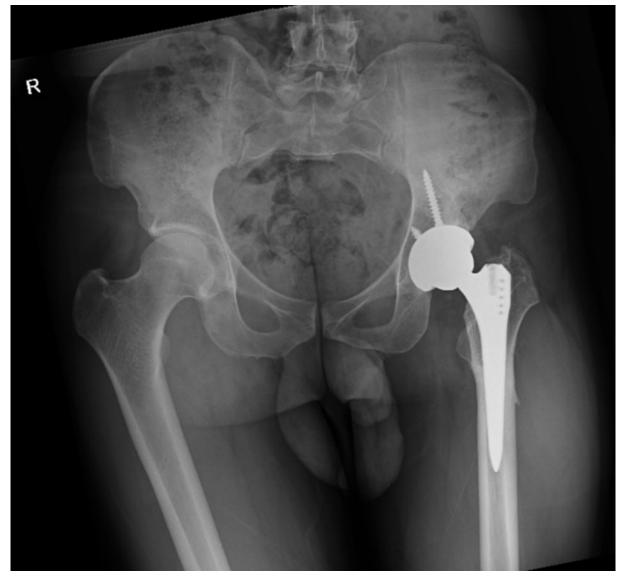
Postoperative x-ray image of a patient.
